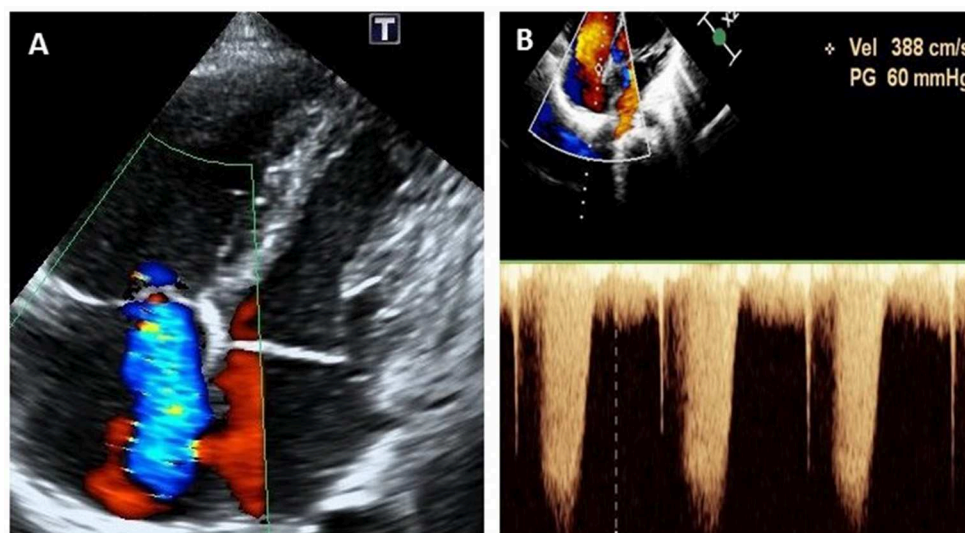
Echocardiogram (apical four-chamber view) at the onset of pulmonary arterial hypertension at 9 years of age, showing severe tricuspid regurgitation (A) and continuous wave doppler estimation of tricuspid reflux velocity 3.88 m/s, PG = 60 mmHg (B).
